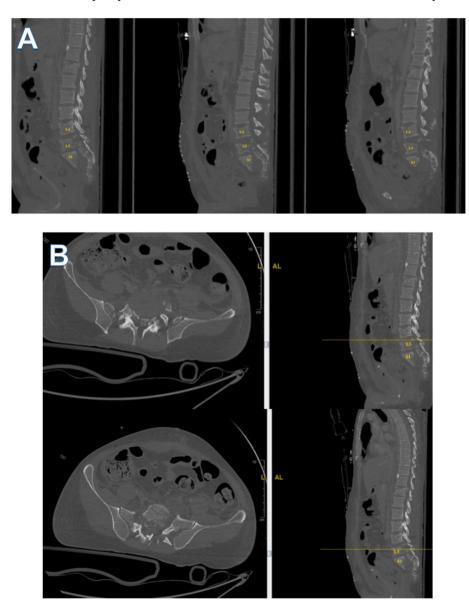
A: Computed tomography (CT) Sagittal cuts upon presentation, showing traumatic L5 sacralization.B: Axial cuts at the level of L5, showing severely comminuted fractures at the lumbosacral area.C: Coronal cut of CT upon presentation, showing traumatic L5 sacralization.
